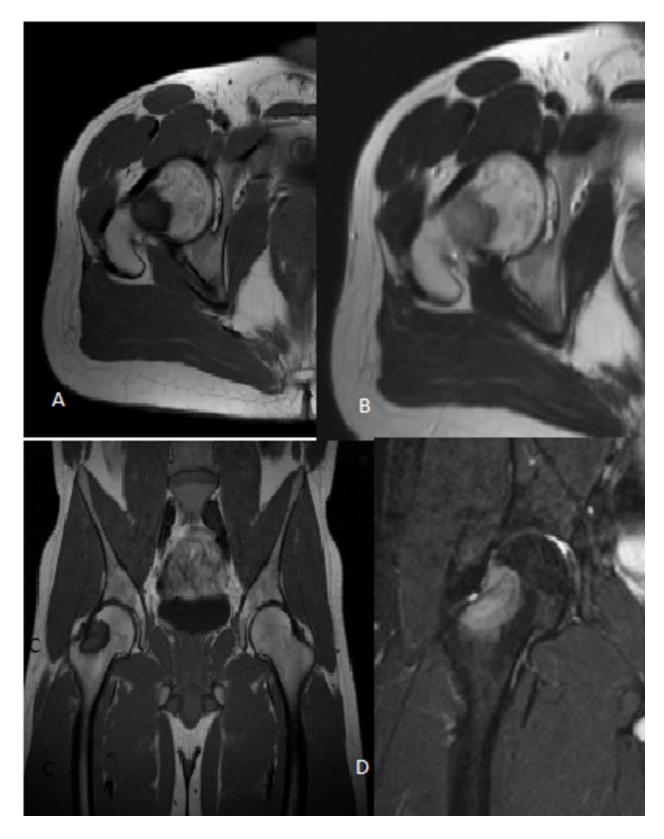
Fibrous Dysplasia. Axial T1-weighted image, axial T2-weighted image. coronal T1 and T2-weighted without fat supression image reveal a small lesion in the right femoral
